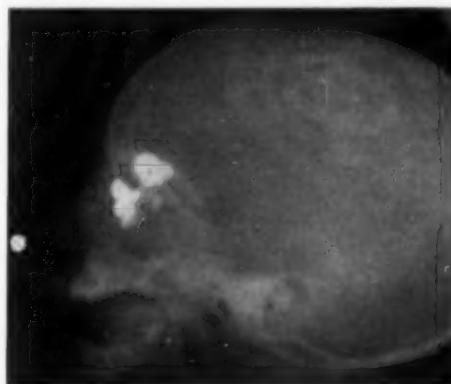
(Ladenheim and Metrick). Right lateral X-ray view five minutes after injection of radiopaque dye.
